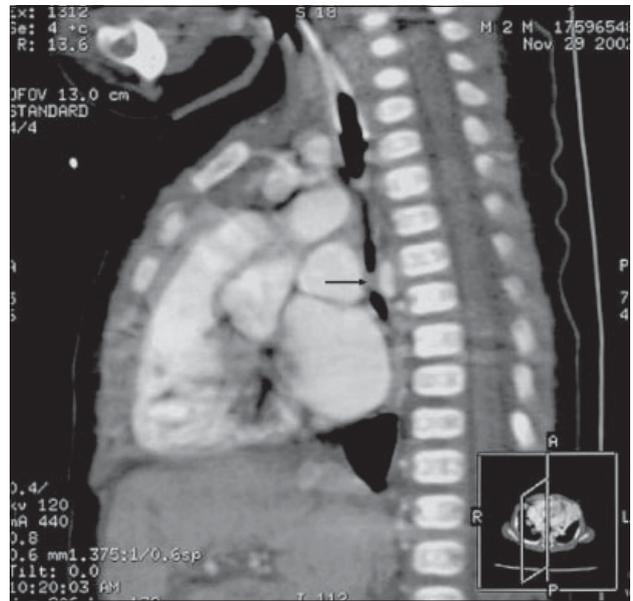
Computed tomogram reconstructed in the sagittal plane showing total occlusion of the distal trachea by the anomalous vessel posteriorly (arrow).
